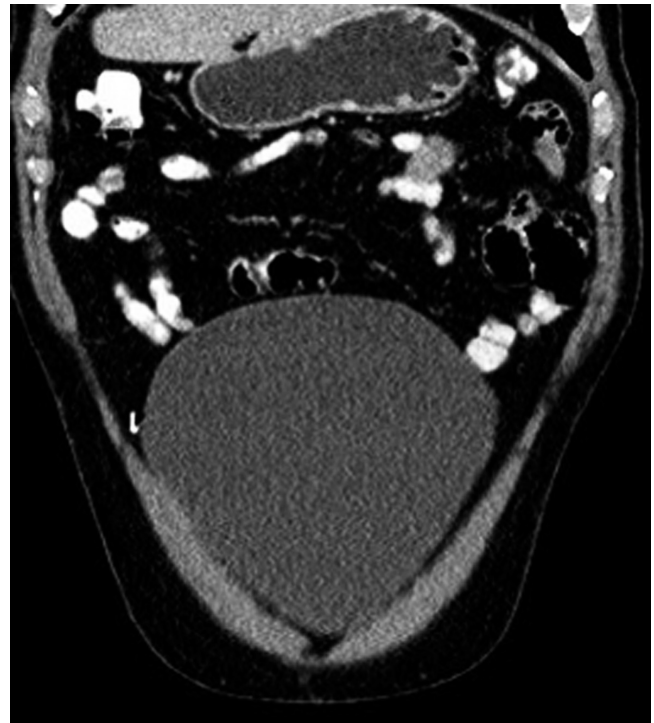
Coronal reconstruction in abdominal CT scan with contrast. Dropped laparoscopic metallic clip. Notice the absence of inflammatory reaction (arrow).
